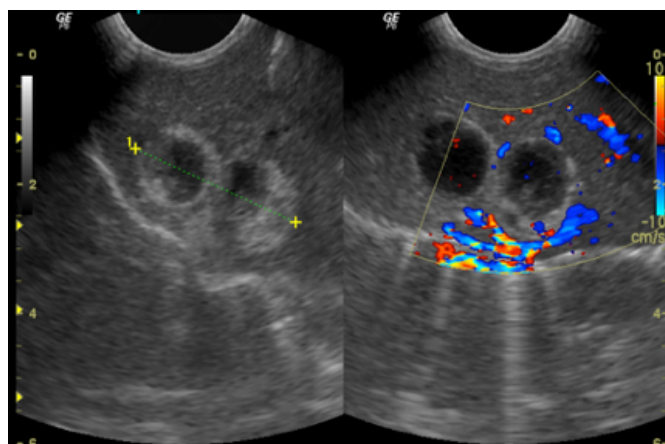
Abdominal ultrasound showing two adjacent cystic formations in segment VIII, with 13 and 17 mm, the largest with some peripheral hyperechogenic areas and the smallest more liquefied, and both without detectable vascularization.
